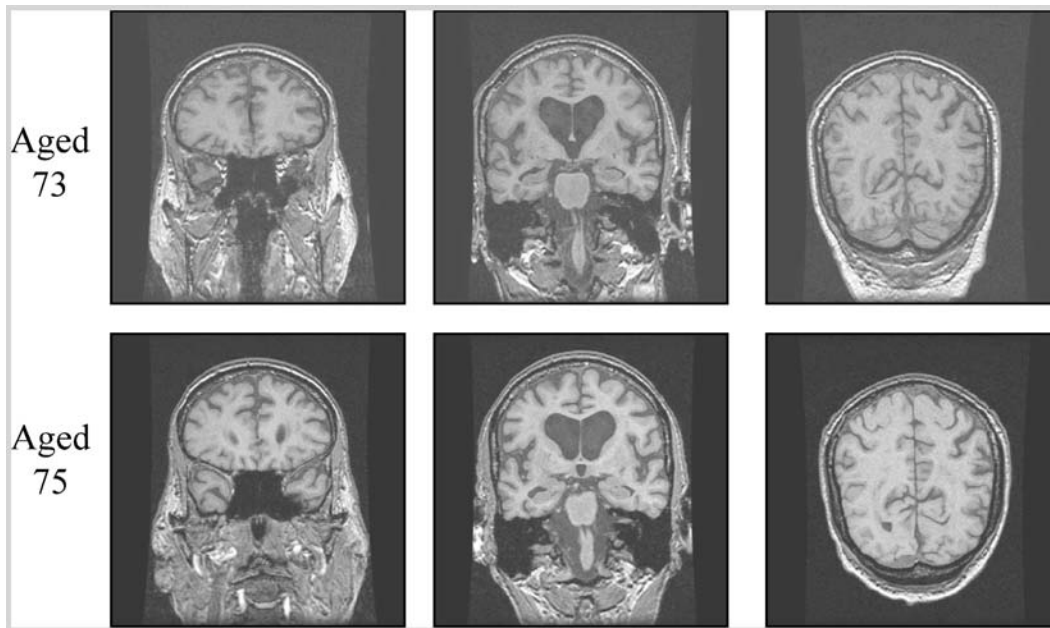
Coronal T1-weighted magnetic resonance images of Case 4-1 at ages 73 (top row) and 75 (bottom row). Note the minimal cerebral cortical and hippocampal atrophy and lack of significant progressive atrophy on these images. Although there is mild ventricular enlargement, there is no evidence of transependymal flow on T2-weighted images (not shown) to suggest normal pressure hydrocephalus.
